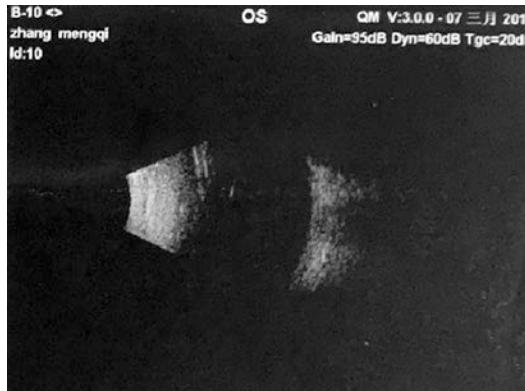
Type-B ultrasonic: normal
